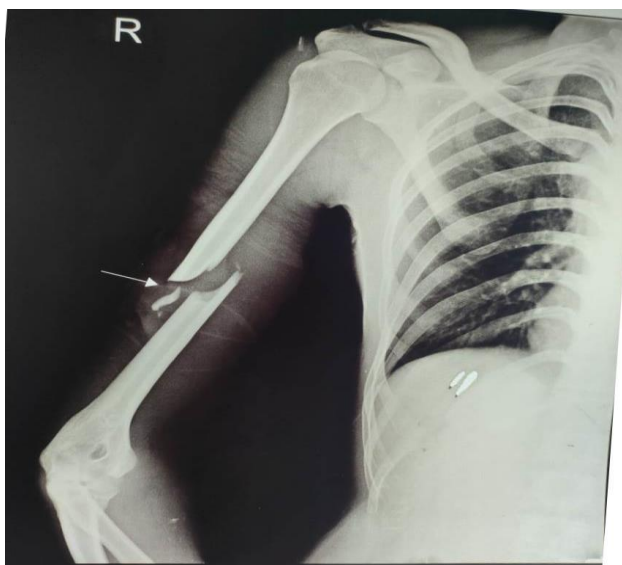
Pre-operative X-ray showing middle third shaft of humerus fracture
